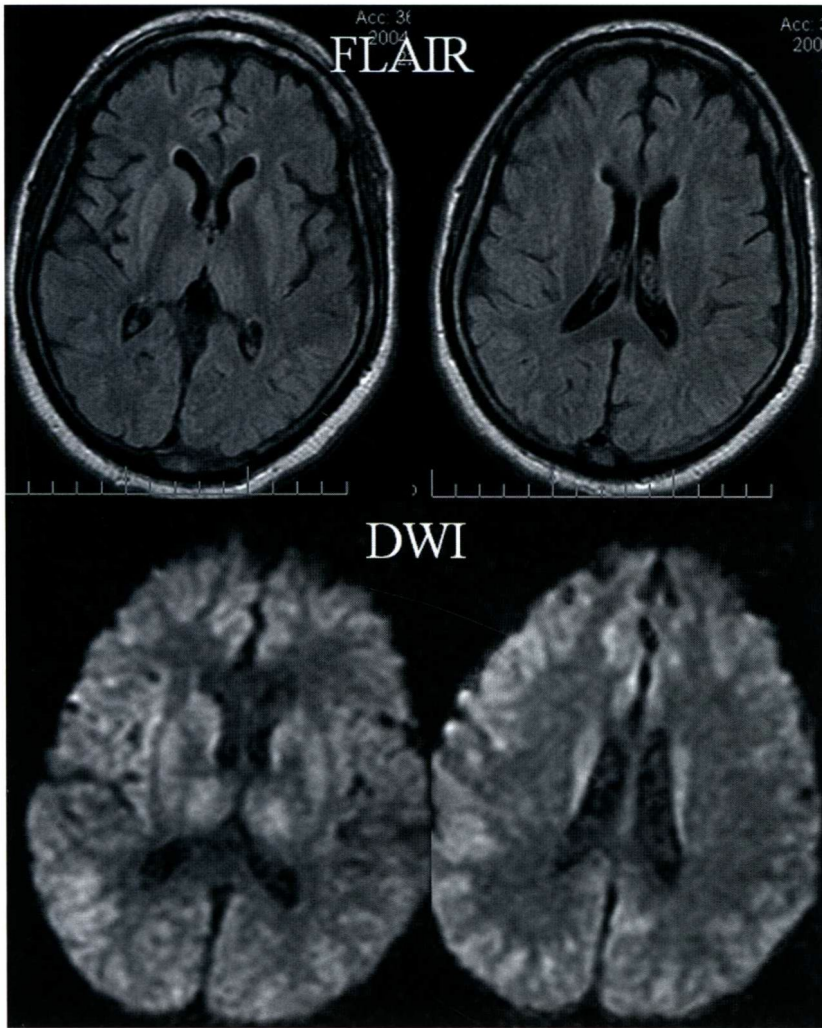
Axial FLAIR and DWI images show diffusely and symmetrically increased signal in the cortex and deep gray matter structures compatible with global anoxic injury. The patient had a cardiac arrest and was declared brain-dead shortly after the MRI.
